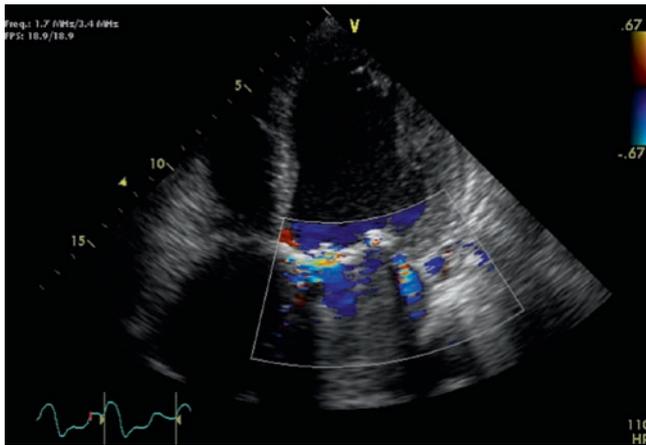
Trans-oesophageal colour Doppler echocardiography showing an extensive intra-prosthetic leakage of a single-tilting-disc prosthesis caused by pannus ingrowth
